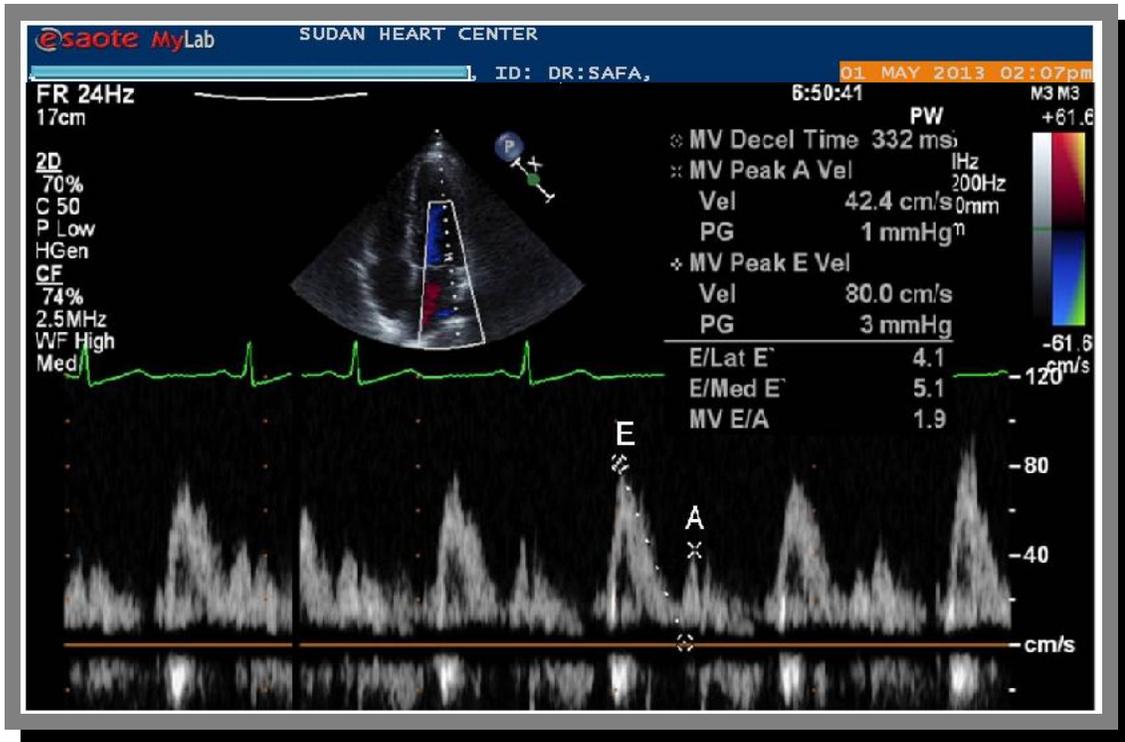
pulse wave Doppler signal of mitral valve.
